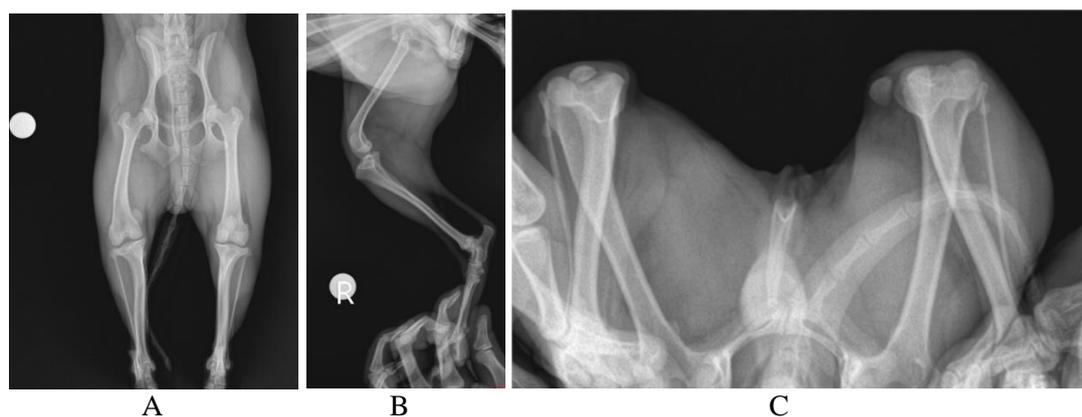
(A) Anteroposterior, (B) mediolateral and (C) skyline radiographs
